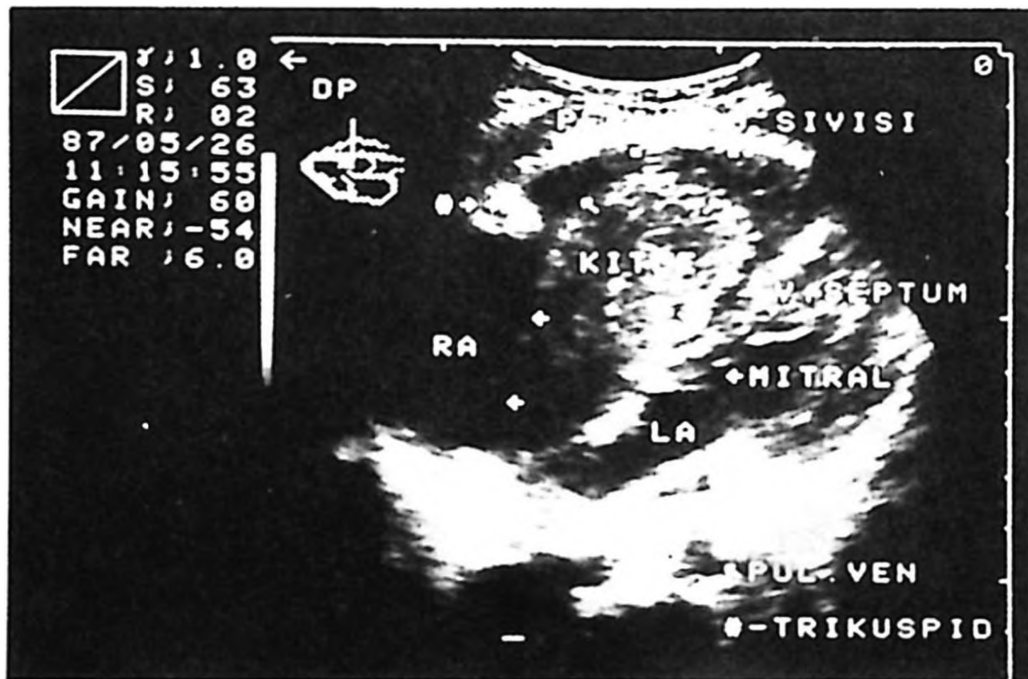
Echocardiogram showing tumoral mass in the right atrium
